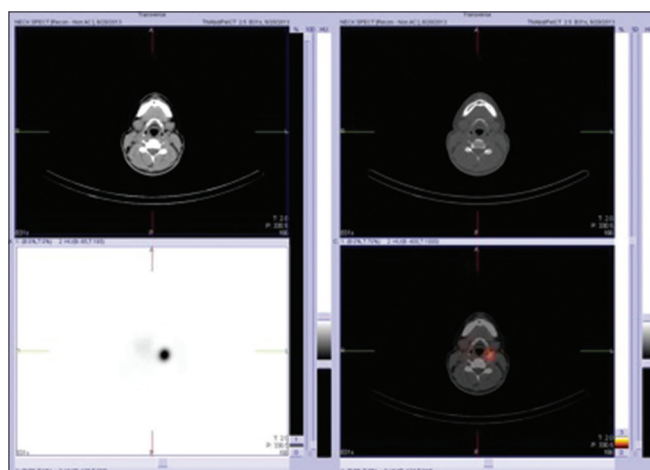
Diagnostic Iodine-131 whole body scan in a patient previously treated for papillary carcinoma of the thyroid. Single-photon emission computed tomography image showed focal area of intense increased uptake of Iodine-131 in the left side of the neck (lower left image). Single-photon emission computed tomography-computed tomography localized the focus of Iodine-131 uptake to a subcentimeter left submandibular lymph node (lower right image)
